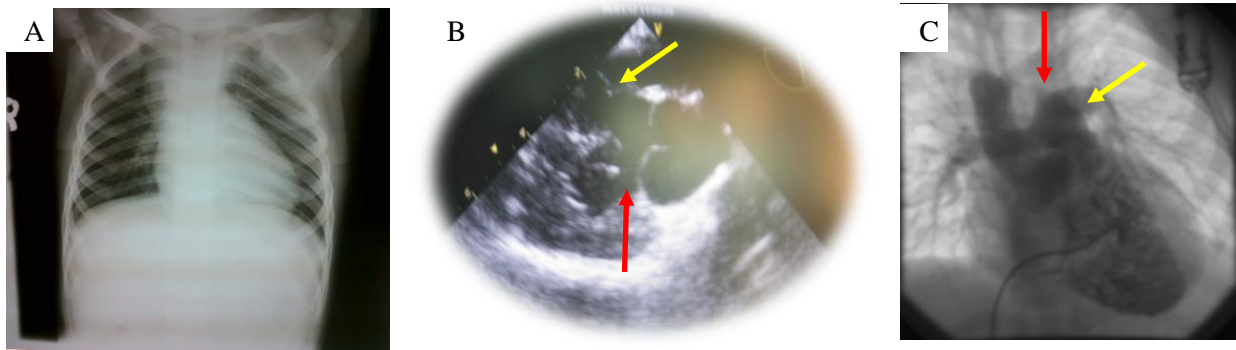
Radiological Examination for TOF (A) X-ray shows "boot shaped" appearance, (B) Echocardiography shows dextroposition of the aorta (yellow arrow) and VSD (red arrow) (C) Angiography shows infundibular stenosis (yellow arrow) and pulmonary artery (red arrow) (Source: Tahalele's Documentation)(26)
